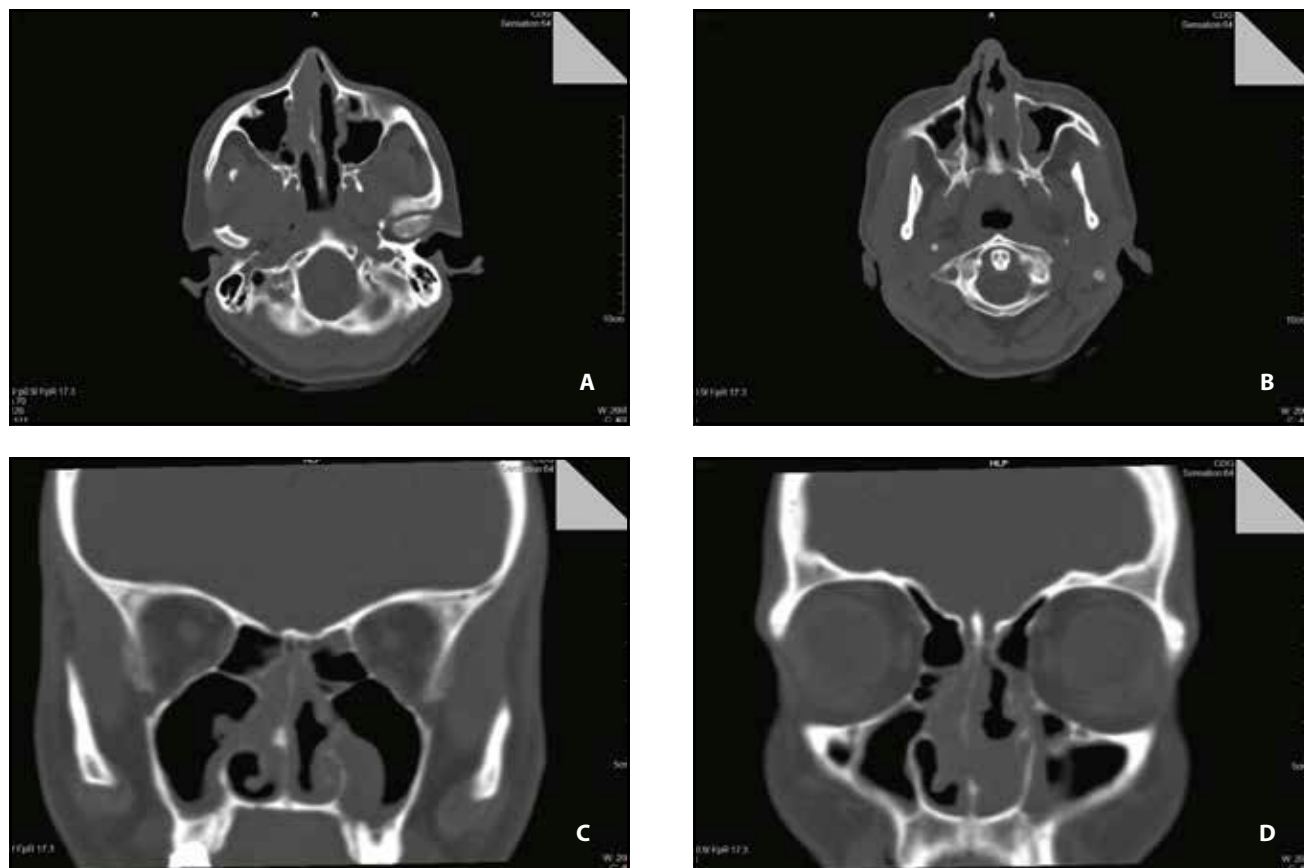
Cranio-facial CT Scan – axial slices (A,B), coronal slices (C,D). Nasal septal tumoral growth with extension predominantly into the left nasal cavity, having an erosive character of the osteo-cartilaginous septal structure, without sinus involvement; stagnating secretions in small quantity in the left maxillary sinus; no ethmoidal involvement, no skull base lysis.
